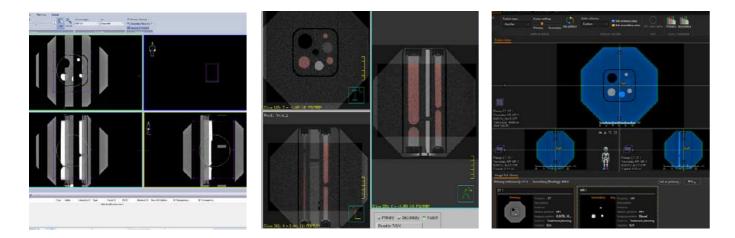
The check of CT / MRI image registration algorithm using the System QA insert
